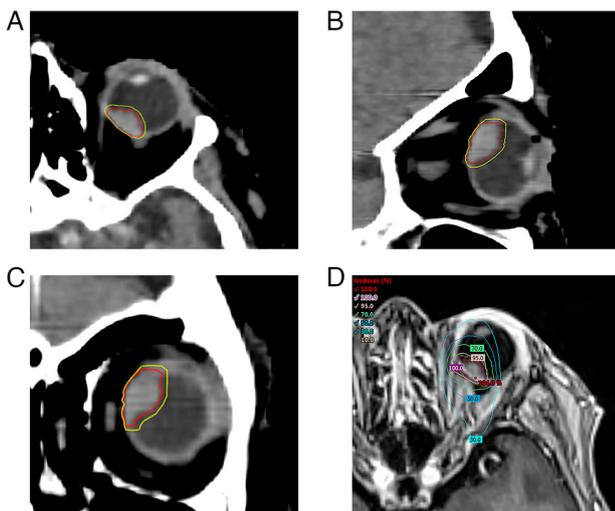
Mapping of the treated lesion of the patient, based on the pre-irradiation therapy brain CT scan fused with the brain MRI in three projections: (A) Axial plane, (B) sagittal plane, (C) frontal plane during the treatment planning. (D) Dose distribution for stereotactic body radiation therapy using the image-guided volumetric modulated arc therapy method. The color wash represents the dose in Gy.
